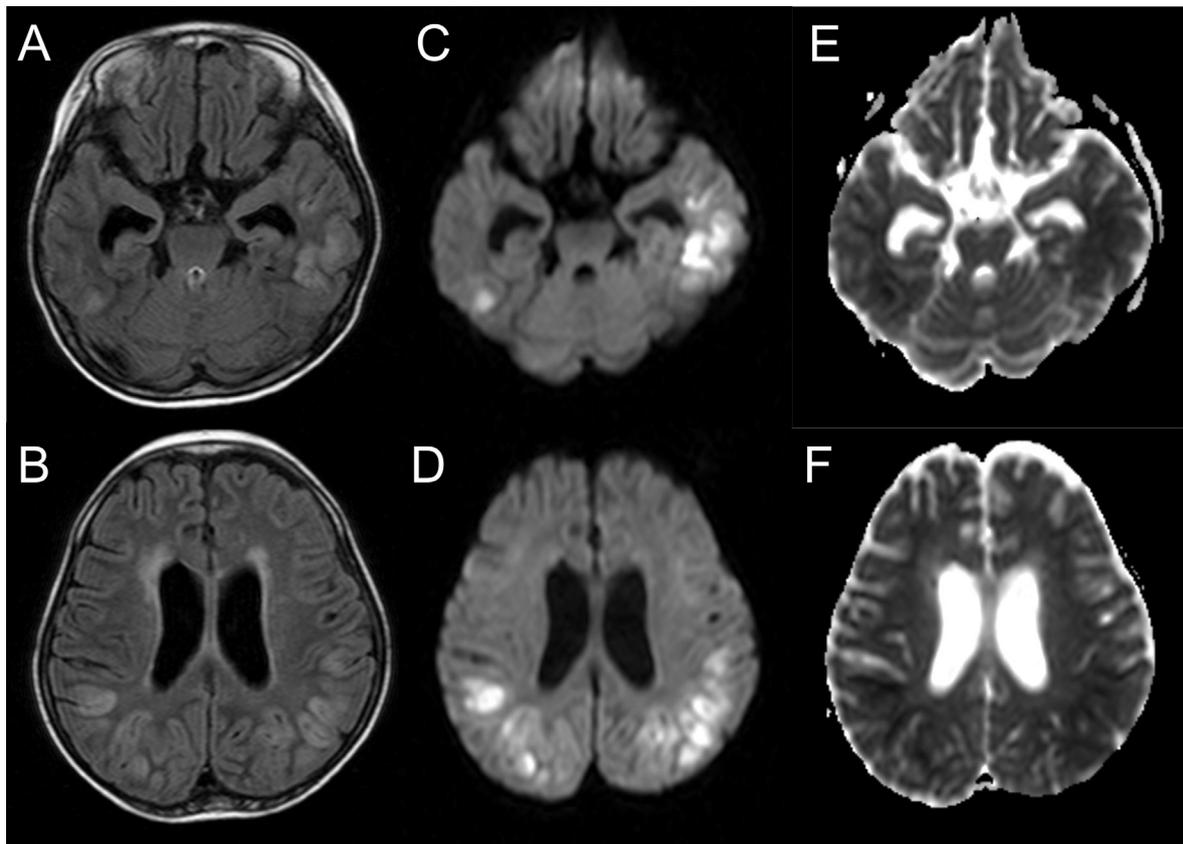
Axial unenhanced MR imaging at 5 days after the first relapse: fluid-attenuated inversion recovery (FLAIR) (A and B), diffusion-weighted imaging (DWI) (C and D), and apparent diffusion coefficient (ADC). FLAIR images show hyperintensity at the cerebral cortex and subcortical regions of the bilateral temporal and occipital lobes. The lesions show hyperintensity on DWI, and hypointensity on ADC. Cerebral atrophy is not clear.
